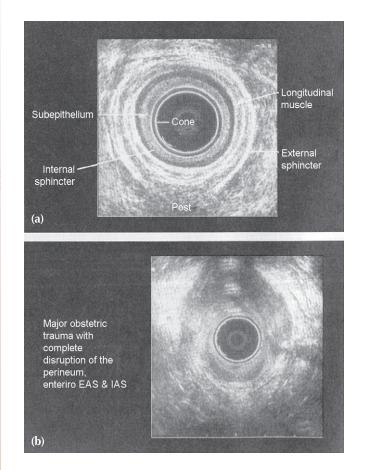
Transrectal ultrasound showing (a) normal anatomy, (b) anal sphincter defects (by courtesy of Prof. Clive Bartram).
